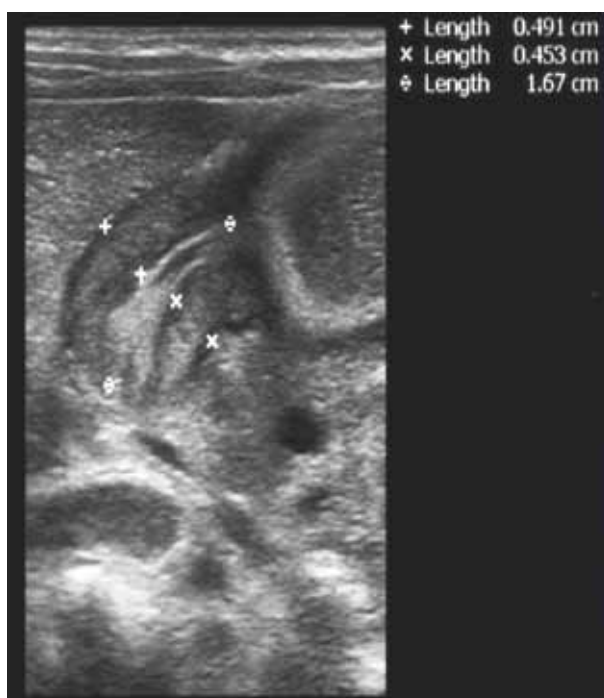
Ultrasound diagnosis of pyloric stenosis
